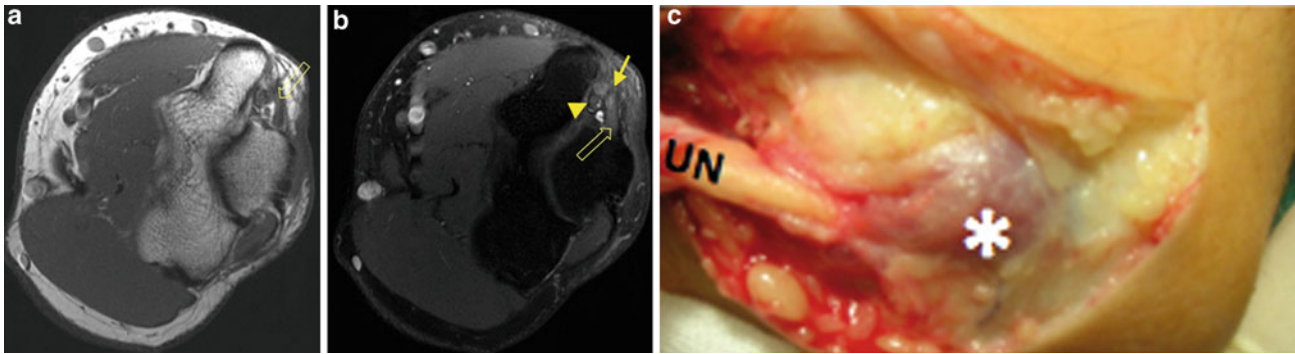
38-year-old man with anconeus epitrochlearis muscle that has led to a cubital tunnel syndrome. The T1-weighted 3 Tesla MR images a show the accessory anconeus epitrochlearis muscle next to the cubital tunnel (*open arrows*). To cure the irritation of the ulnar nerve, the muscle has been split surgically (*closed arrow*). The fat-saturated contrast-enhanced T1-weighted MR image b demonstrates that the nerve exhibits no pathologic enhancement (*arrowhead*) and that the accessory muscle shows postoperative subtle enhancement. Furthermore, the intraneural T2 signal of the ulnar nerve was normal
